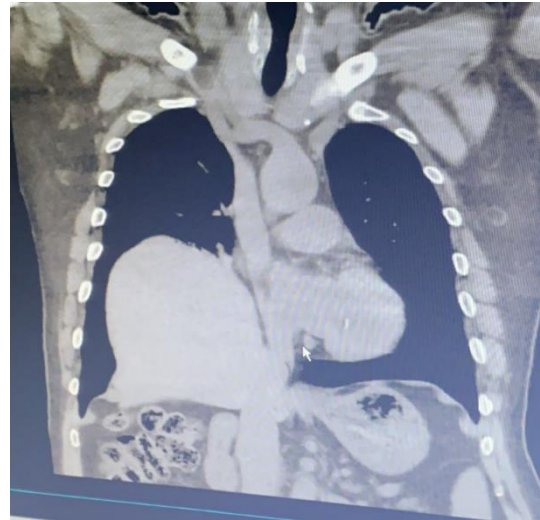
Thoracic Computed Tomography (CT)
